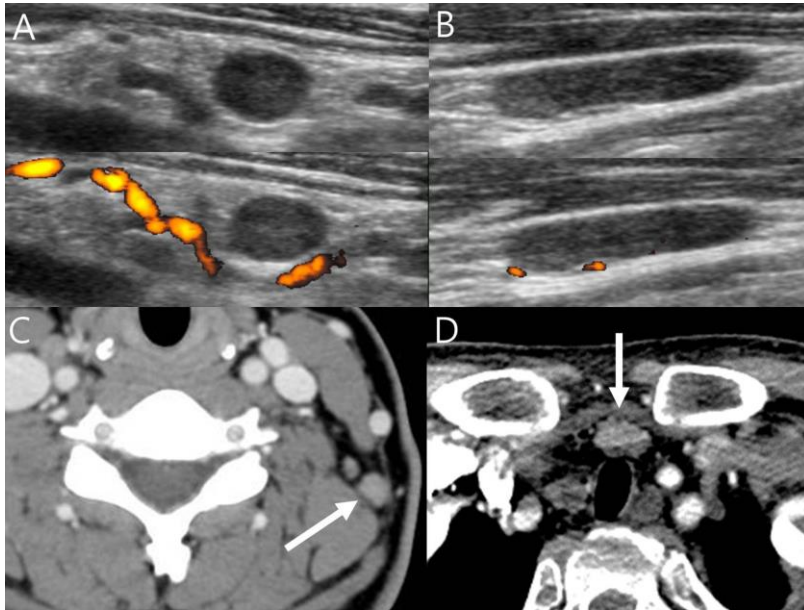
Indeterminate lymph nodes. A, B. The US features of the indeterminate lymph nodes. The US images shows ovoid and elongated lymph nodes which show loss of central echogenic hilum and central hilar vascularity. Note the absence of any suspicious US feature in these nodes. Diagnosis: Probable benign lymph node (FNA not performed). C, D. The CT features of the indeterminate lymph nodes. The CT images show lymph nodes that do not have a central fat hilum and central hilar vessel enhancement. Note the absence of any suspicious CT feature in these nodes. Diagnosis: Probable benign lymph node (C, FNA not performed), metastatic papillary carcinoma (D).
